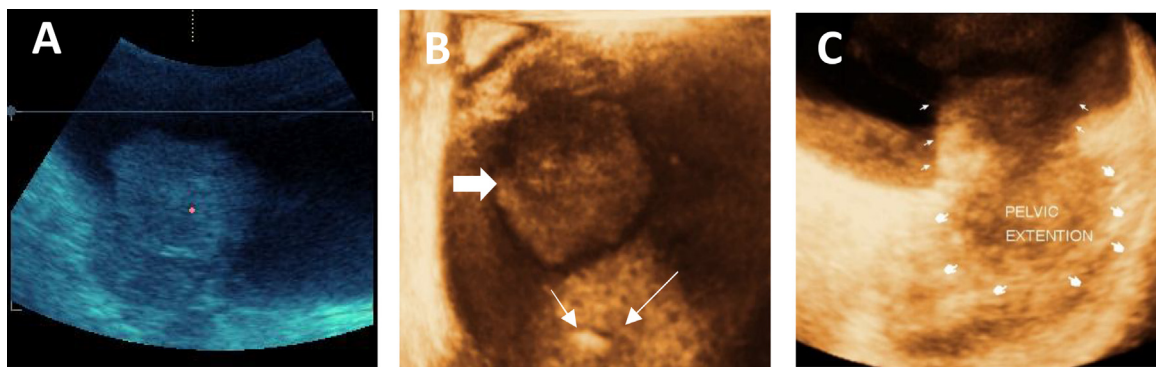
Male patient 67 years old presented with hematuria and elevated kidney functions . (A) Transverse grey-scale ultrasonography revealed a hyperechoic lesion 6 cm on the posterior wall of the bladder.(B) Surface rendered 3D sonography from a different angle shows an additional small polypoid mass (small arrow) on trigone of the bladder and the same polypoid mass (large arrow) on the posterior wall of the bladder.(C) cut section of reconstructed 3D images showing extra vesical extension (white pointers).
